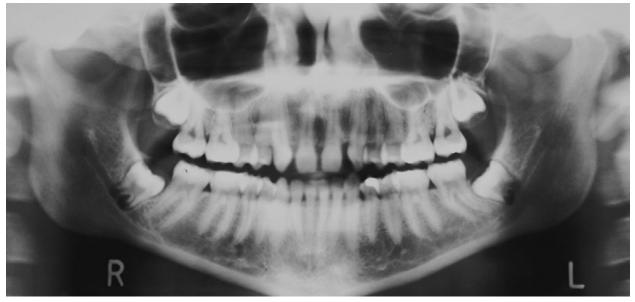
Panoramic radiograph of congenitally missing maxillary lateral incisor teeth #7 and #10.
